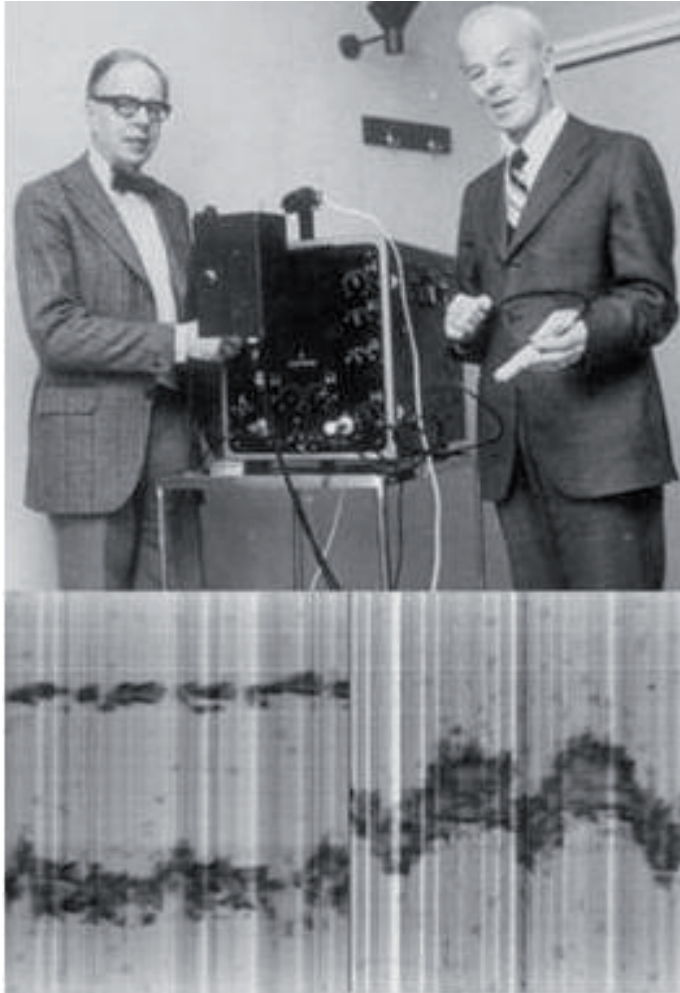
Helmuth Hertz (*left*) and Inge Edler (*right*) registering the very first recording of the ultrasound echo of the heart
